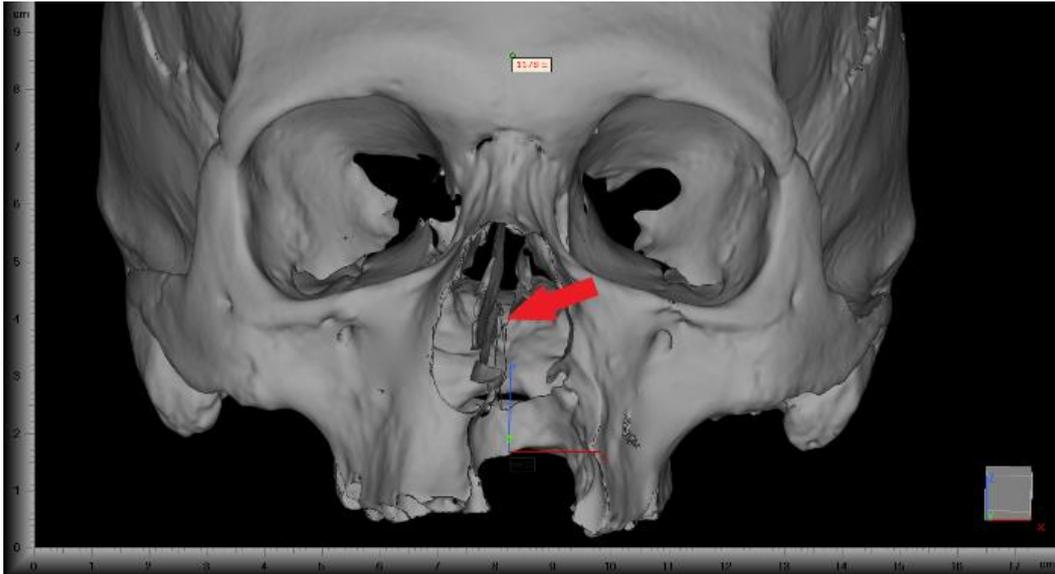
CT images of the male individual Nr.1178
